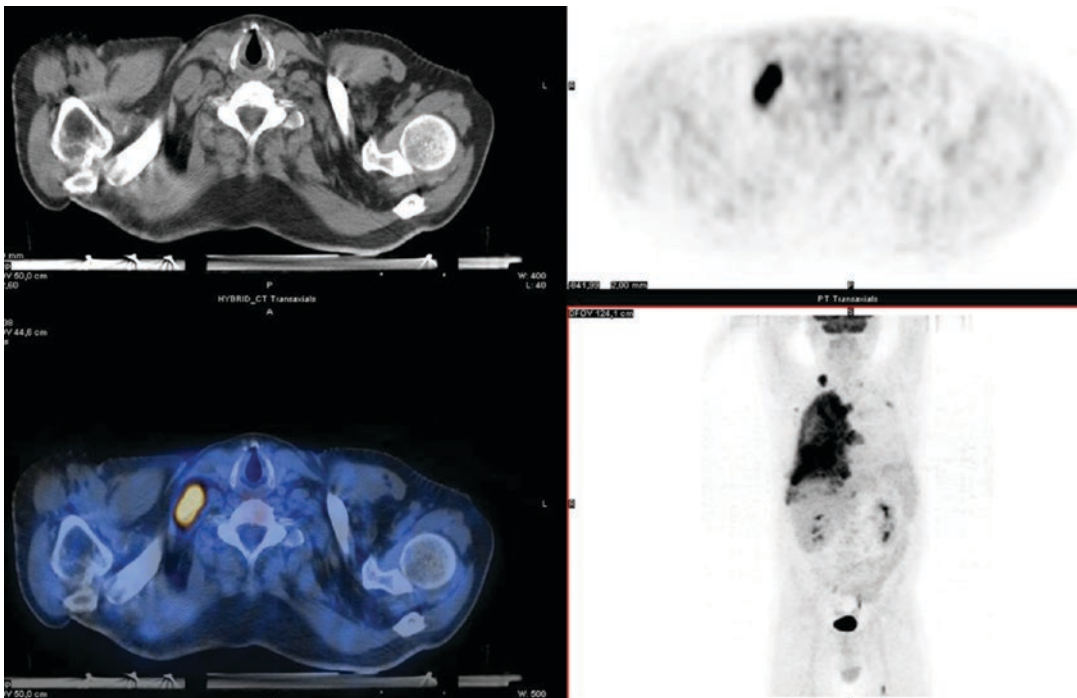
PET/CT is helpful in distinguish between N2 and N3 disease, detecting lymph node involvement in contralateral internal mammary, contralateral hilar region, ipsilateral supraclavicular or scalene region
